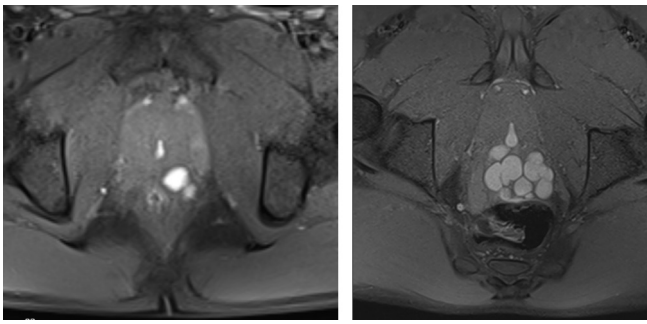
2021 pelvic MRI (axial and sagittal sections): Dilation in the left seminal vesicle (red arrow), ejaculator duct obstruction (yellow arrow)
